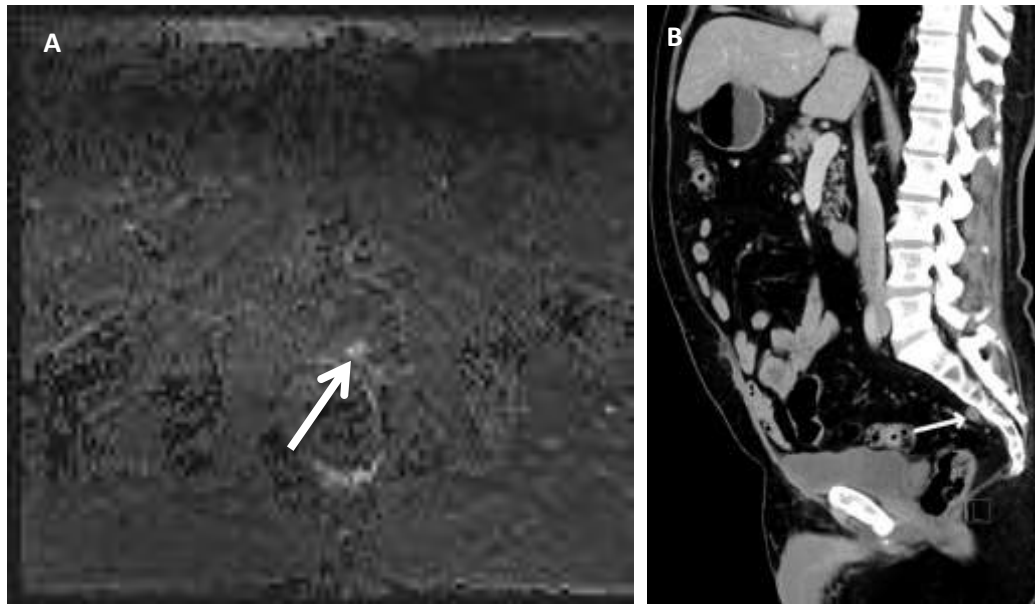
An example of locoregional recurrence at prostatectomy site demonstrated on Axial dynamic contrast-enhanced MRI imaging in patient BCR007 (white arrow).
